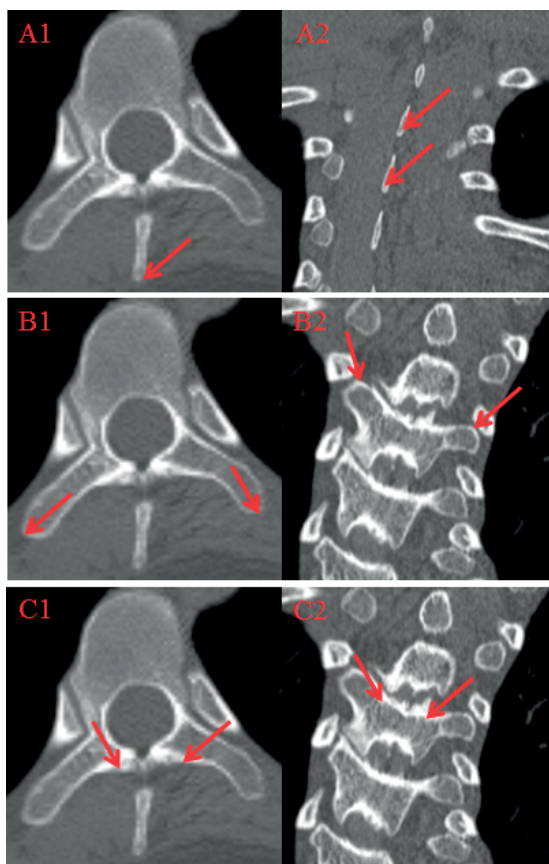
CT image with (1) transversal and (2) sagittal view of a vertebra with marked in red the location of the (A) spinous process tip (SP), (B) transverse process tip (TP) and (C) center of lamina point.
